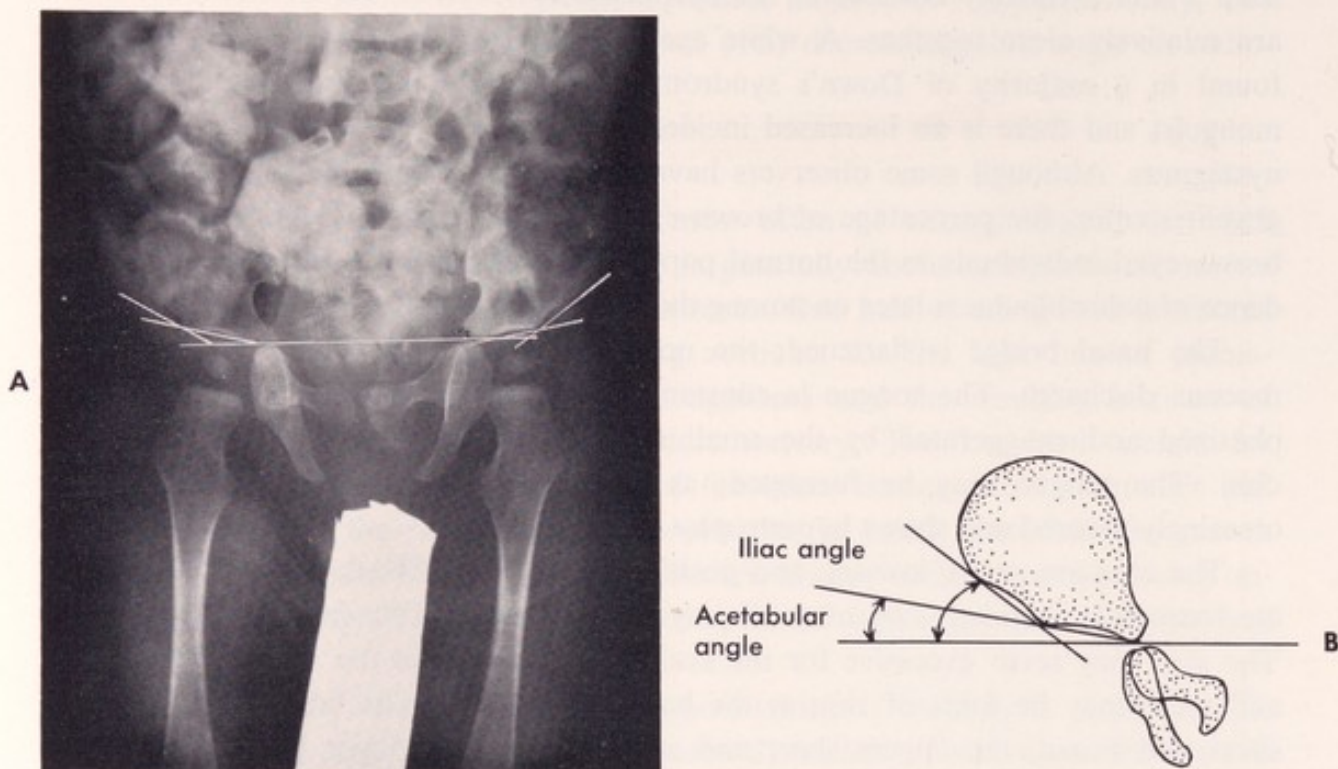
A, Radiograph of the pelvis of a child with Down's syndrome and, B, a diagnostic sketch demonstrate narrow acetabular and iliac angles. These measurements are useful only up to approximately 3 months of age. (Courtesy Dr. Lawrence Davis, Louisville, Ky.)
